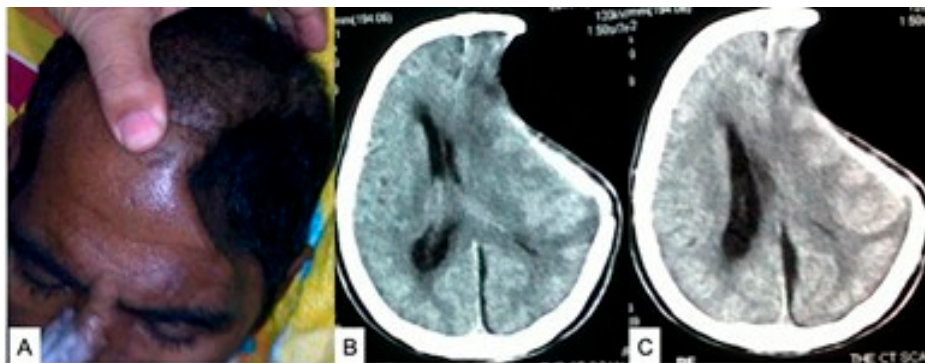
Post-DC sinking skin flap syndrome (SSFS): (A) the head of a patient with SSFS; (B,C) CT scan of the head (axial views) of the patient. Source: Figure by authors.
